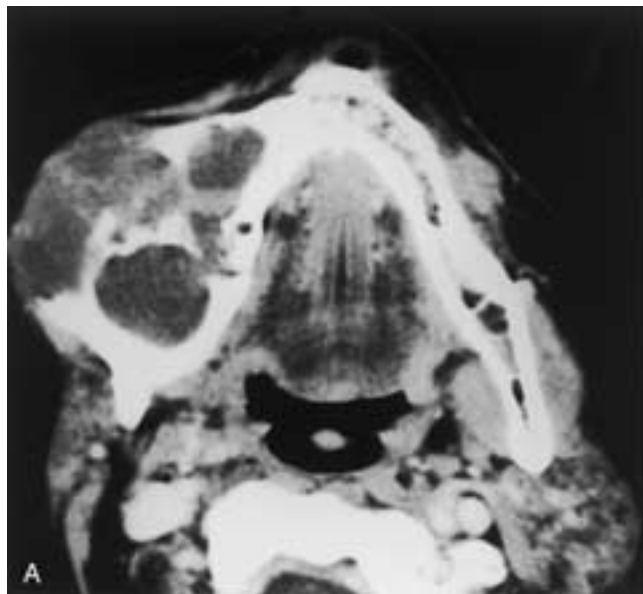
Ameloblastoma. Axial contrast-enhanced CT scans filmed at (A) soft-tissue and (B) bone window settings demonstrate a large, poorly circumscribed, destructive lesion of the right mandible. The tumor is enlarging at the expense of the buccal aspect of the mandible. There is an overall “soap-bubble” appearance to this lesion, which appears to contain both solid and cystic components. (Courtesy of Dr. Thomas Underhill.)
